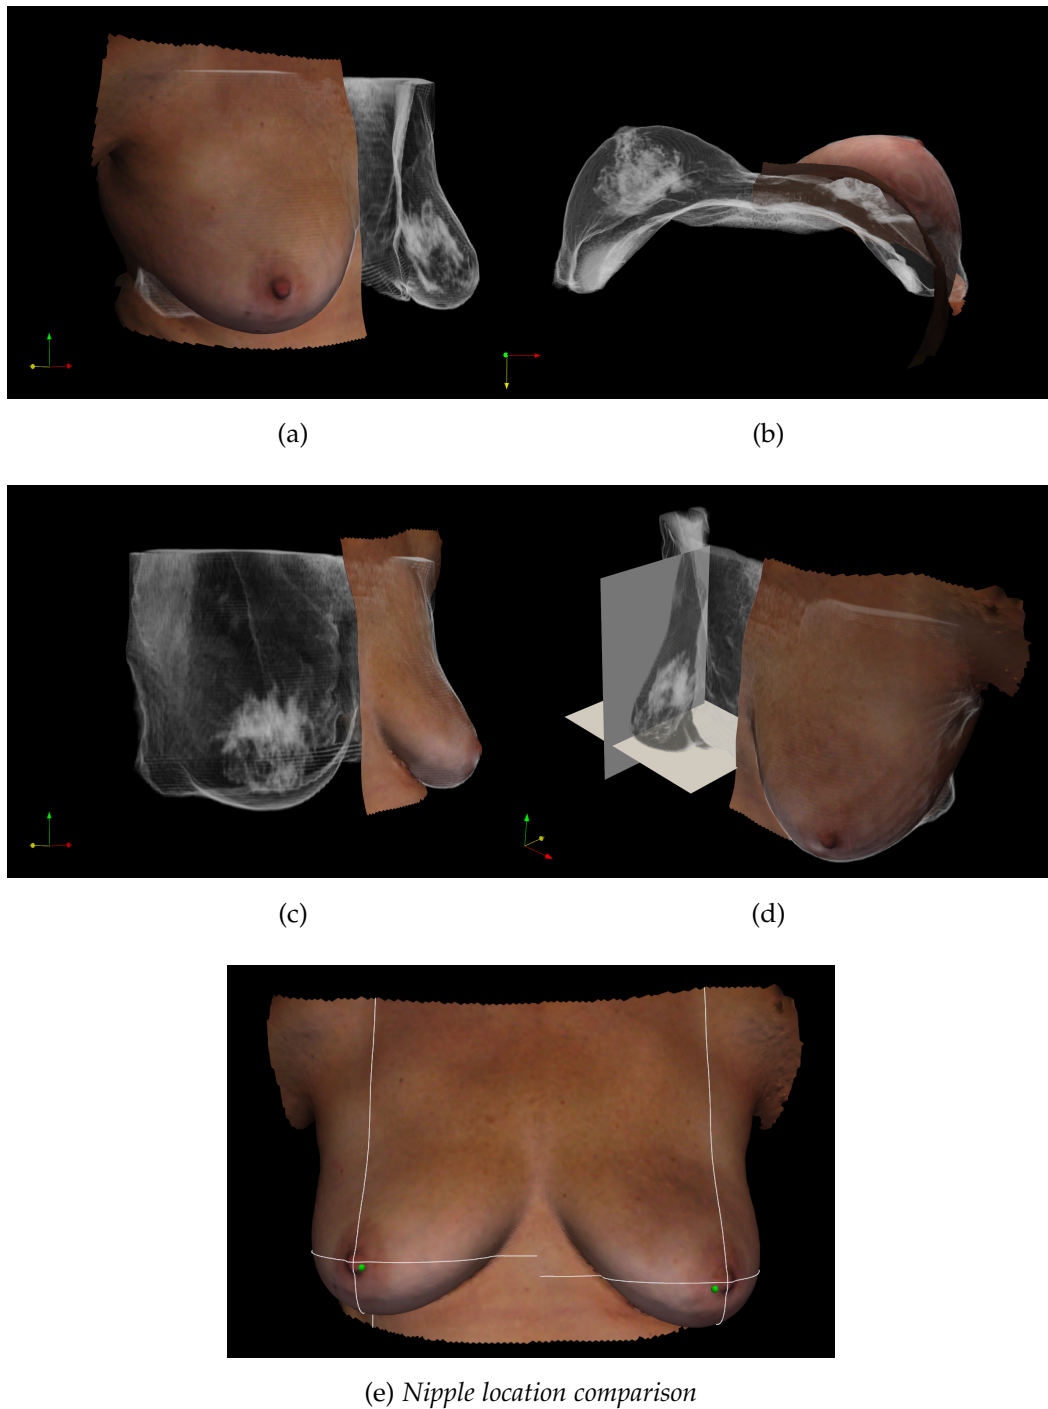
Result of the surface driven registration approach that aligns a prone MRI to an upright optical 3D surface scan of the same patient. A volume rendering of the transformed MR image and the target surface is shown in figures (a)-(d). Figure (e) shows the nipple location identified in the warped MRI as green spheres and those in the surface scan as cross-hairs.
